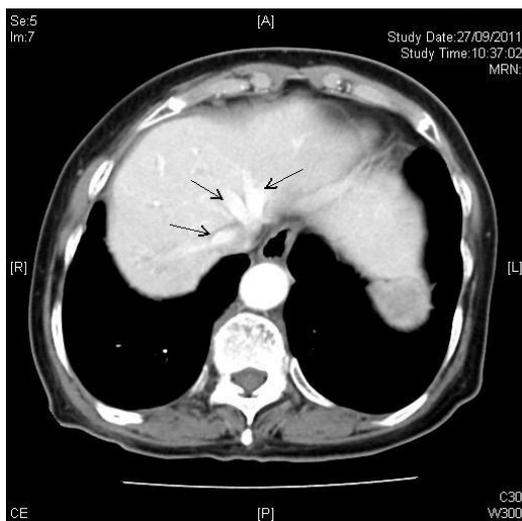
Contrast-enhanced CT of abdomen arterial phase image. Early filling of right, middle and left hepatic veins.
